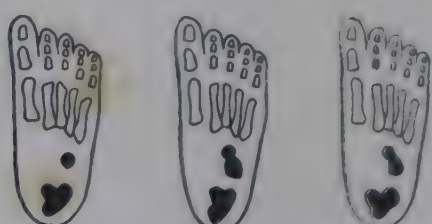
Normal maturation of the bones of the feet from birth to 1 year expressed as percentiles. (From Caffey, J.: *Pediatric X-Ray Diagnosis* [2d ed.; Chicago: Year Book Publishers, Inc., 1950]; according to Stuart.)
